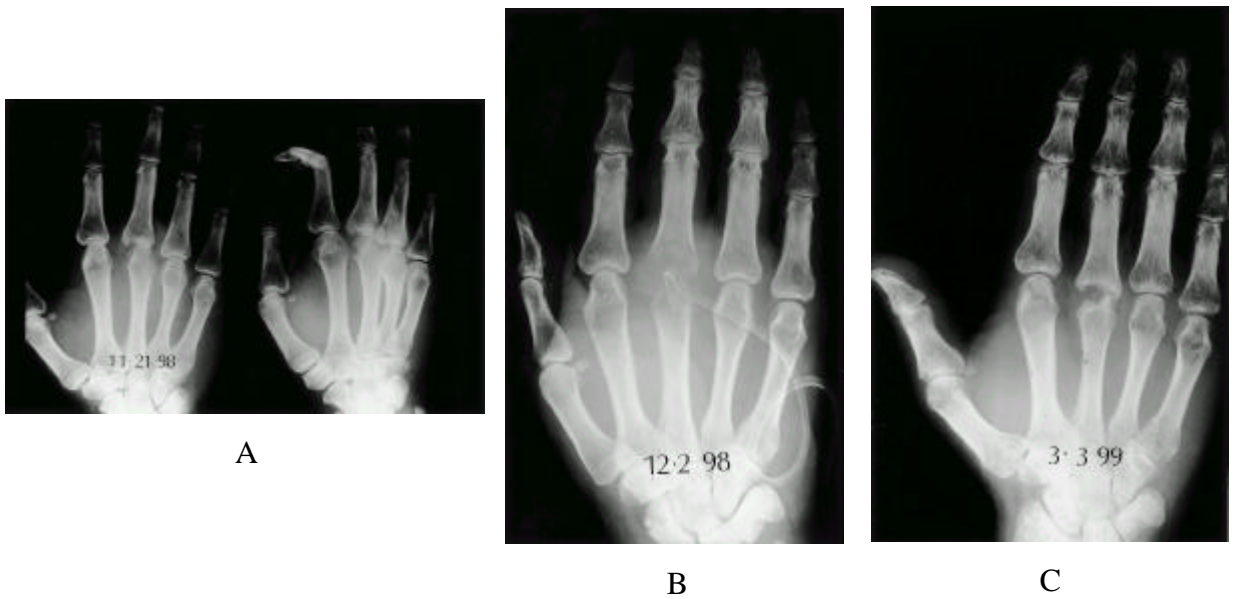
A Initial radiographs of right hand AP and oblique show no bony abnormalities. B. After debridement and irrigation, articular cartilage was severely damaged. C. Radiographs of post trauma 5 months show articular cartilage was destroyed state.
